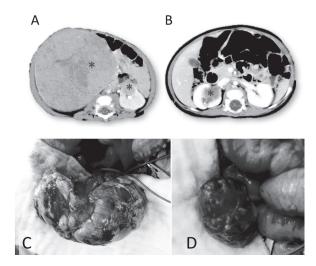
A case of bilateral Wilms tumor. A-B) CT scans demonstrating tumors (asterisks) and reduction of tumors after chemotherapy C) Operative findings of the remaining tumor on the right kidney D) The right kidney after nephrectomy.
